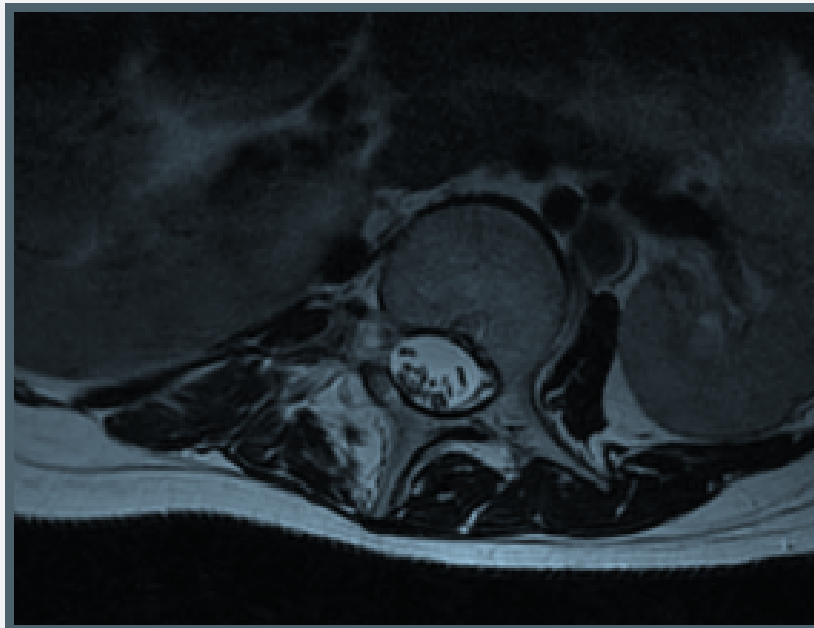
Lumbar spine MRI in T2 sequence demonstrating marked lumbar levoscoliosis. The same study reveals possible situs inversus (spleen on the right), right kidney agenesis, and left kidney ptosis, consistent with VACTERL syndrome.
